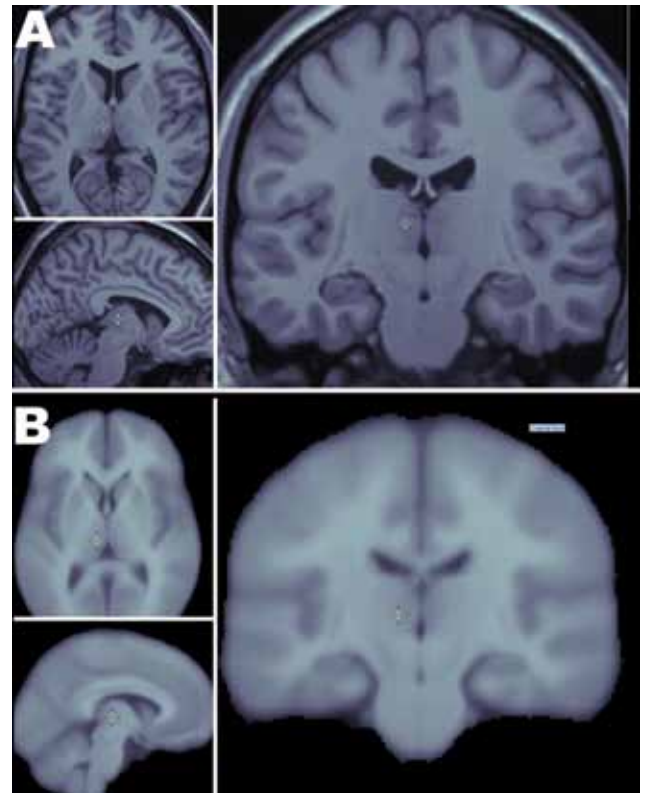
Anatomical variability of cerebral anatomy across 452 patients (ICBM 452 Atlas). A: Axial, sagittal, and coronal views of a T1-weighted MR image of a single patient's brain, demonstrating the high degree of precision with which a single patient's cerebral anatomy can be imaged. B: Axial, sagittal, and coronal views of the average brain of 452 patients who were imaged using the same imaging protocol as that in A. In this “average brain,” patients' brains were linearly transformed into a common space using a 12-parameter affine transformation.
